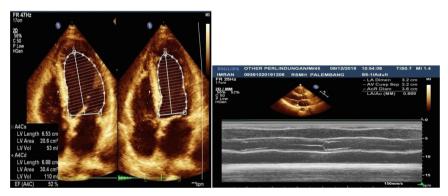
Echocardiography precorangiography.
